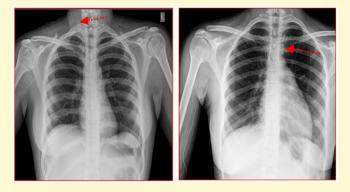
Frontal radiographs showing malpositioned PICC. The tip of the PICC in (A) Right jugular vein, (B) left innominate vein.
